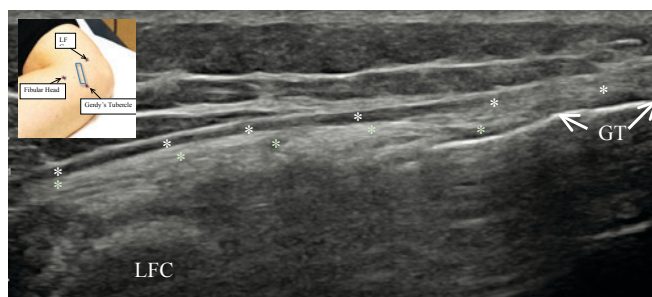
Inset picture showing approximate transducer positioning. Note regional bony landmarks have been marked with a marker on the skin. Sonographic image is the corresponding ultrasound picture at 90 degrees of knee flexion. We typically scan the posterior half of Gerdy's tubercle to find hyper-echoic, bright structure deep to posterior iliotibial band to find anterolateral complex. Transverse view is also obtained but omitted from this article due to space constraint. Left: proximal. Right: distal. LFC: lateral femoral condyle, GT: Gerdy's tubercle, White asterisk: posterior iliotibial band, Green asterisks: anterolateral complex.
